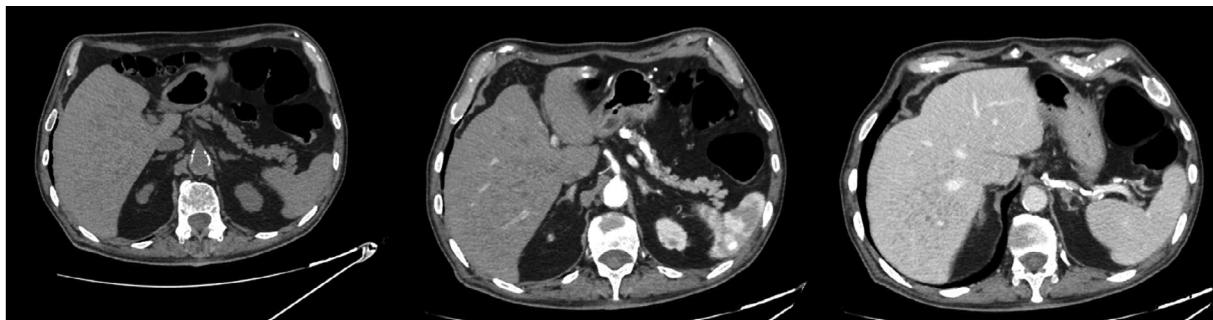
Axial CT image: hypodense lesions without significant contrast enhancement in the arterial and venous phases.
